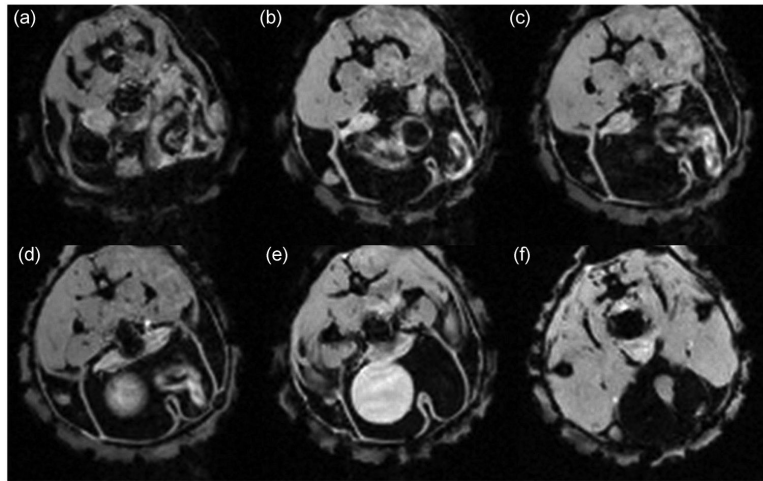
Low-resolution screening MR images of similar slices as shown in Fig. 1. MIN lesions identified in Fig. 1C are not as well visualized on lower resolution scans. FOV is $\sim 2.25 \times 2.25$ cm.
